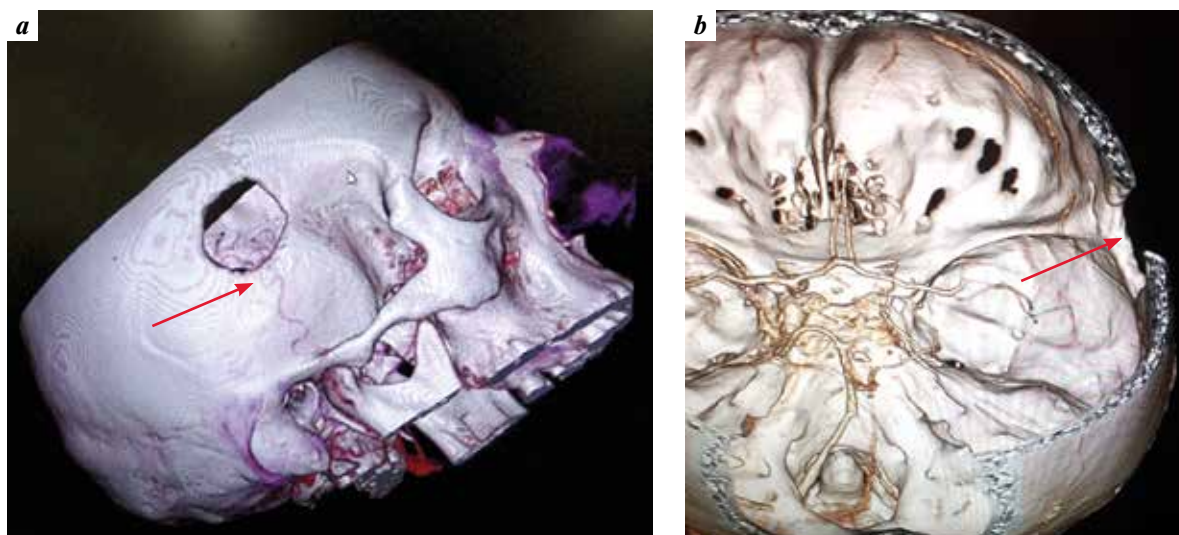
3D spiral computed tomography angiography of patient T.: *a* – functioning low-flow STA-MCA bypass in the early postoperative period; *b* – nonfunctioning low-flow STA-MCA bypass on the right 4 years after surgery: thrombosis of the left superficial temporal artery is visualized (arrow)
